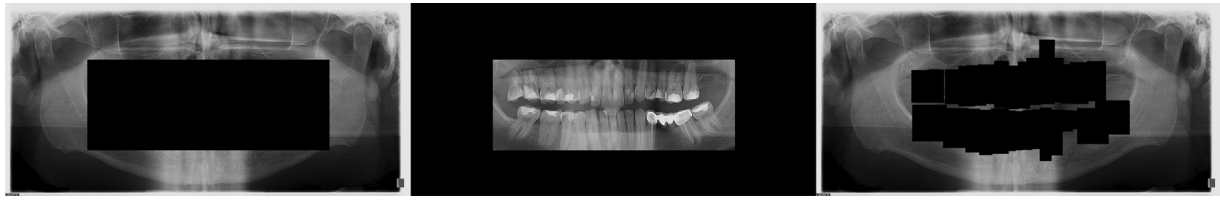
Samples of the panoramic dental X-ray image variants. Models are trained on either images with the teeth area covered (left), images where only teeth area is visible (middle), or images where each tooth is individually covered (right).
